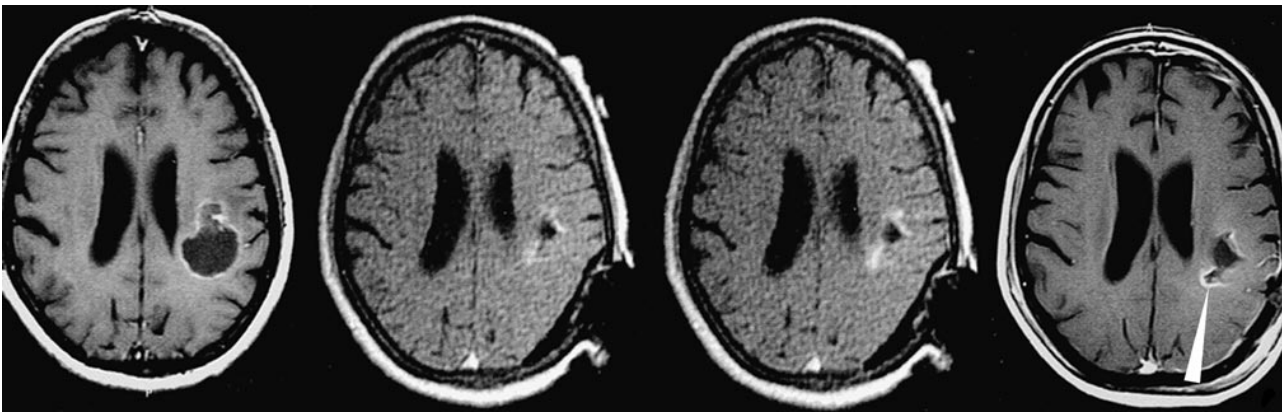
Surgically induced enhancement: problematic case. Preoperative MR (left) (674/20/2) shows a ring-enhancing lesion. Intraoperative T1-weighted images (middle images, 5 and 20 minutes postcontrast) (532/15/3) show enhancement at the resection margin with some time dependence. A confident differential diagnosis of this enhancement (tumor or not?) could not be made, and the surgery was terminated. Early postoperative MR image (right) (674/20/2) shows possible residual tumor (arrowhead).
